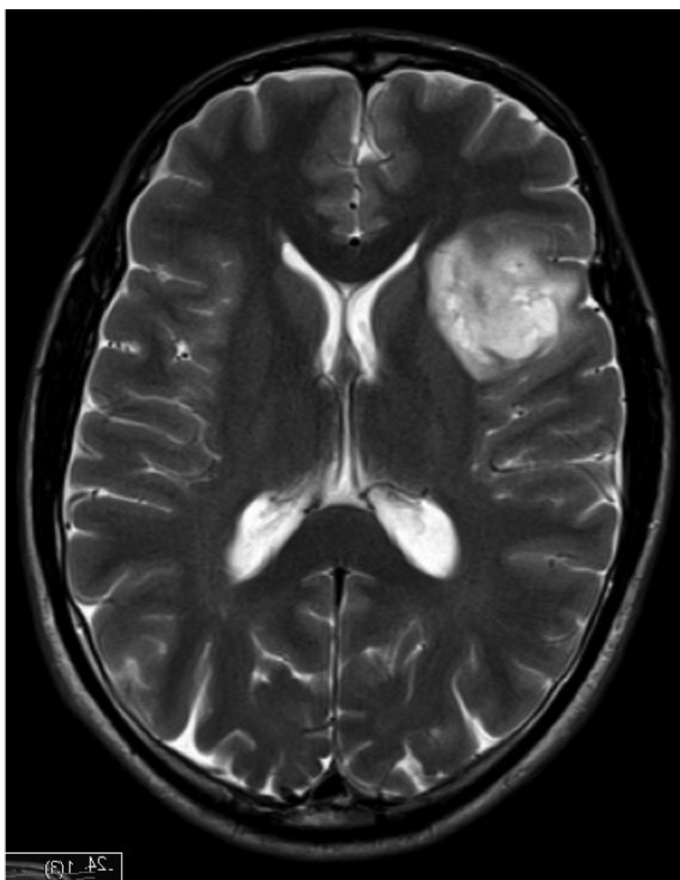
Preoperative MR image of a tumor patient. The tumor is visible in the upper right quadrant of the brain.
